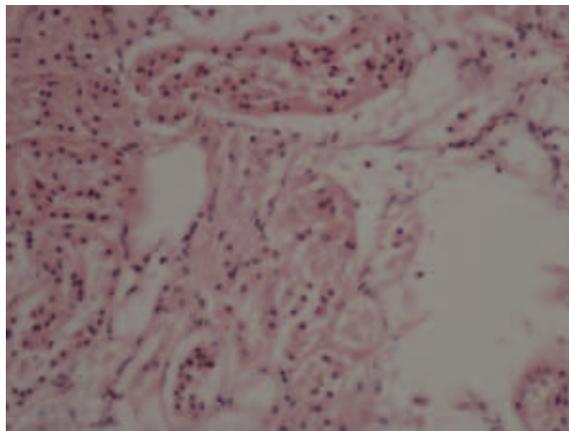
Disruption of kidney tissue caused by high focused ultrasound. A) Sonication time 120 sec
